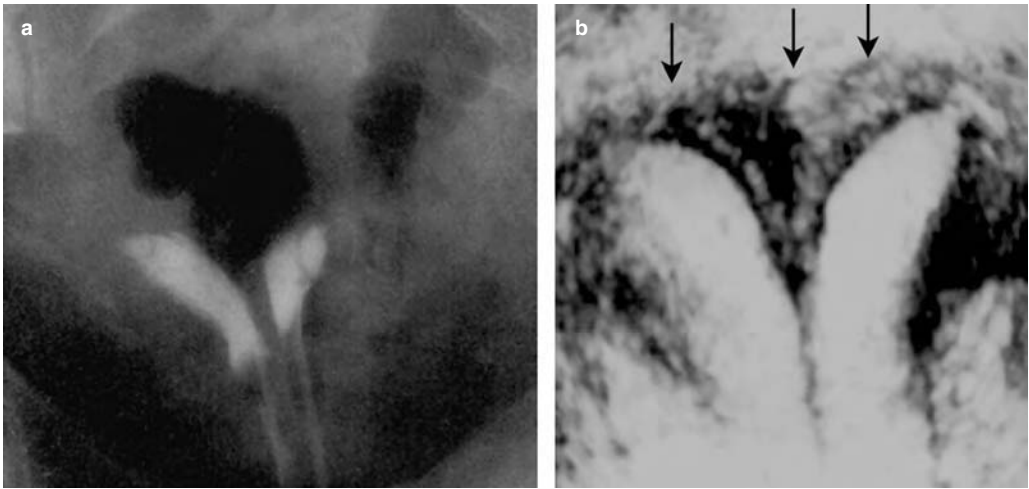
Is the uterine anomaly a septate or bicornuate uterus?* Panel (a) shows a uterine duplication anomaly confirmed by an HSG. Two separate cervixes were cannulated and two separate uterine horns were noted. Panel (b) shows a three-dimensional ultrasound image of the uterus on the same patient. The black arrows note the border of the outer extent of the myometrium of the uterine fundus. The conclusion – *this anomaly is a uterine septum*
